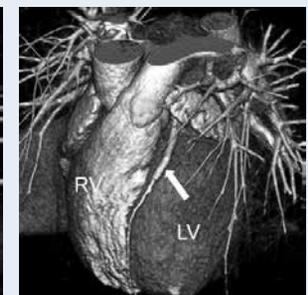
3D reconstruction of coronary CT with LV, RV and LAD after stent implantation (arrow)
